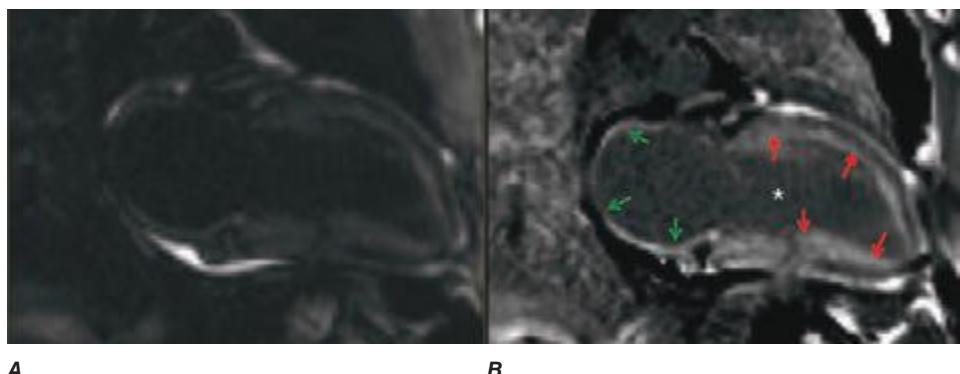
14 Magnetic resonance image with contrast enhancement in magnitude (A), and phase-sensitive reconstructed images (B) 5–10 min after injection of gadolinium in a patient with transthyretin (TTR)-mediated amyloidosis. The phase-sensitive reconstruction (B) enhances the region of abnormal collection of gadolinium, making gadolinium enhancement in the ventricle (red arrows) and the atrium (green arrows) more prominent. Amyloidosis causes accumulation of abnormal interstitial proteins, which results in late gadolinium enhancement in a diffuse subendocardial pattern (red arrows). Blood pool signal is characteristically dark (asterisk) owing to sequestration of gadolinium into other organs.
